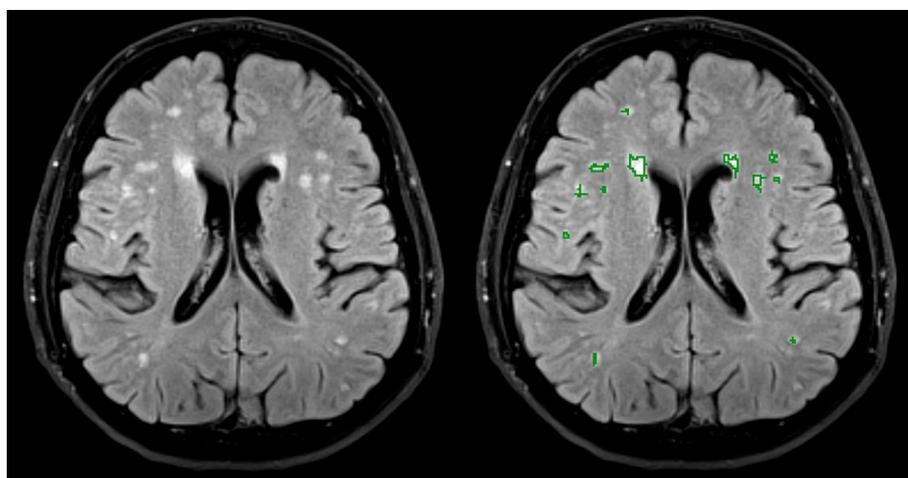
On the left, one slice of the native T2-weighted FLAIR MRI brain scan. On the right, the same slice with white matter lesions manually delineated, using Slicer.
